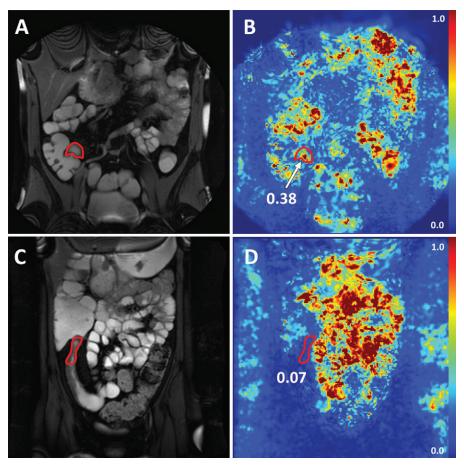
Anatomic reference MR images in, A, a healthy 32-year-old man and, C, a 19-year-old man with neoterminal ileal Crohn disease along with, B, D, corresponding Motility maps. Region of interest at terminal ileum is indicated in red along with Motility score depicting high motility (B) and low motility (D).
